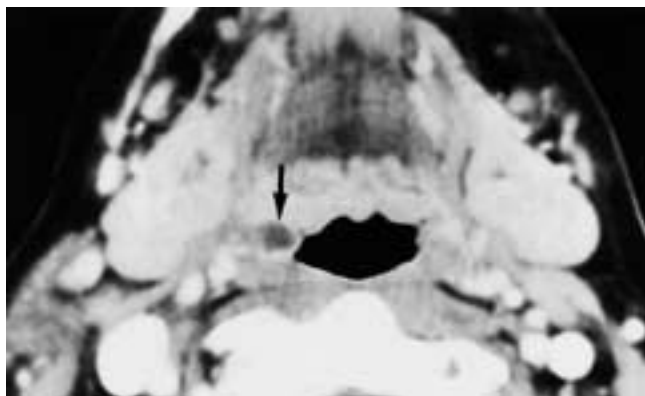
Axial CT scan shows a well-delineated low-attenuation lesion in the right palatine tonsil (*arrow*). The patient had no symptoms referable to this lesion, which has an incidental tonsillar retention cyst.
